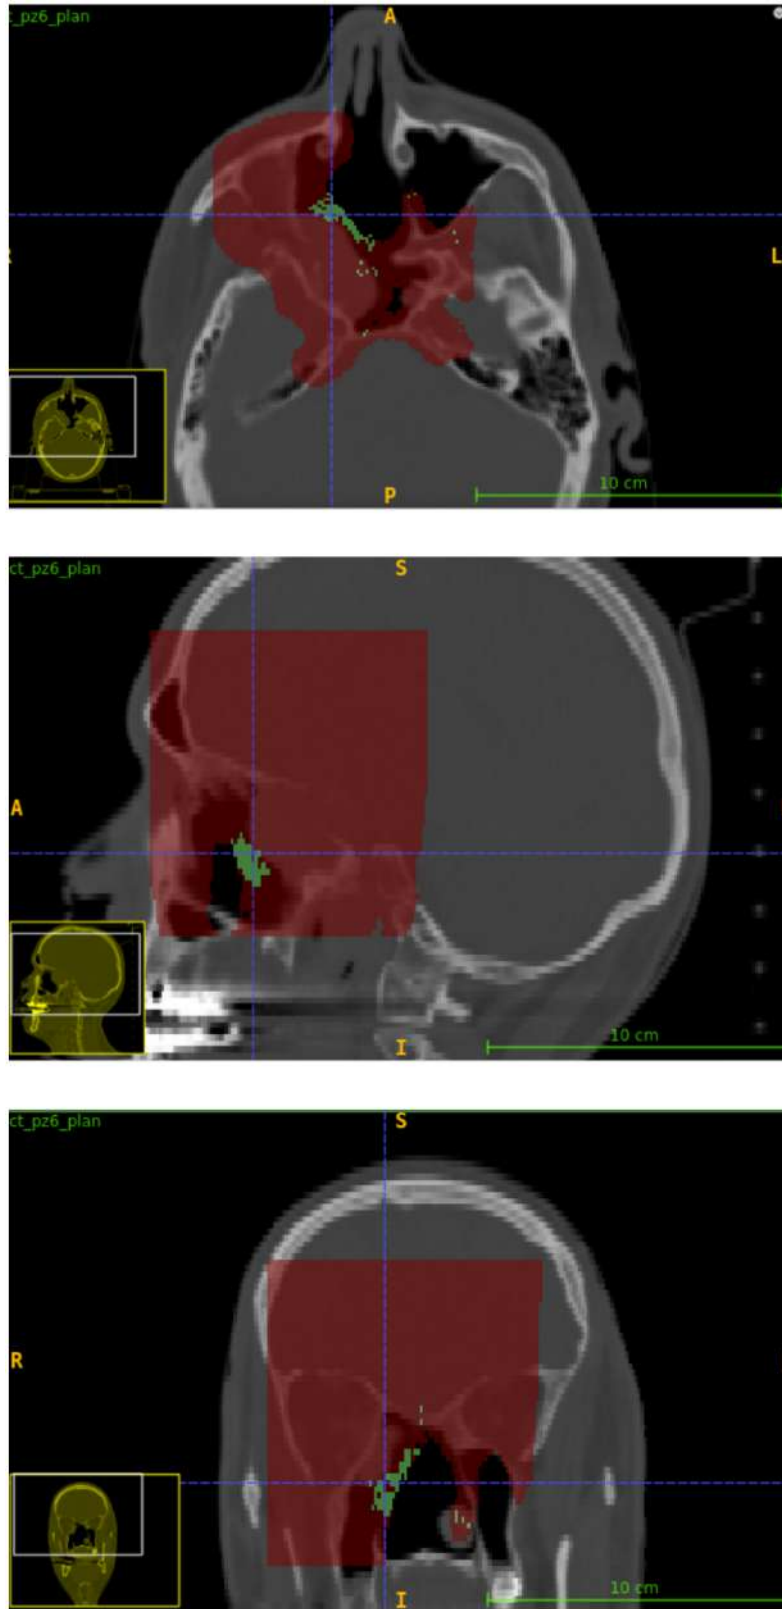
Pass rate map for  $DD = 55\%$ ,  $DTA = 8\text{ mm}$ ,  $DTH = 0.5\%$  in axial, sagittal and coronal views (from top to bottom), overlaid on the planning CT.
